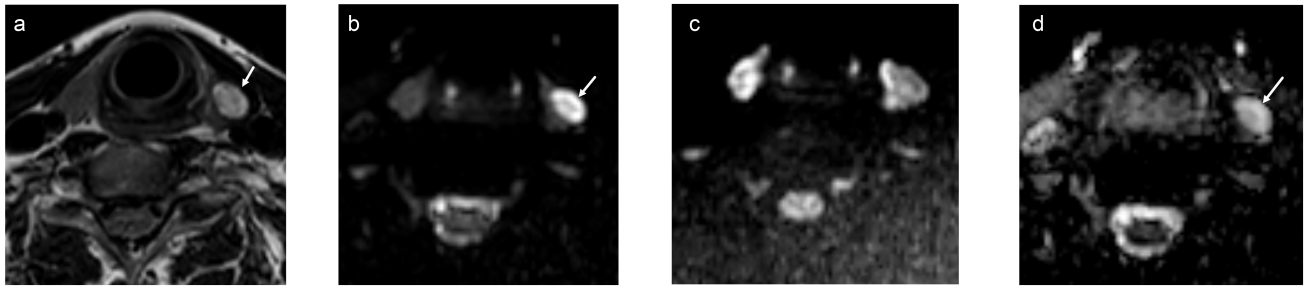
A 43-year-old female with a left thyroid nodule. On FNA biopsy, atypia of undetermined significance (Bethesda category III) was reported. (A) T2-weighted image shows a hyperintense solitary nodule in the left lobe of the thyroid gland (arrow). The nodule-to-muscle T2-weighted signal intensity ratio is 5.592. (B,C) DWI images at b=0 and b=1000. (D) ADC map showing the thyroid nodule with an ADC value of 2.157 and nodule-to-spinal cord ADC ratio 1.893. The final surgical diagnosis was microfollicular adenoma. FNA, fine-needle aspiration; ADC, apparent diffusion coefficient; DWI, diffusion-weighted images.
